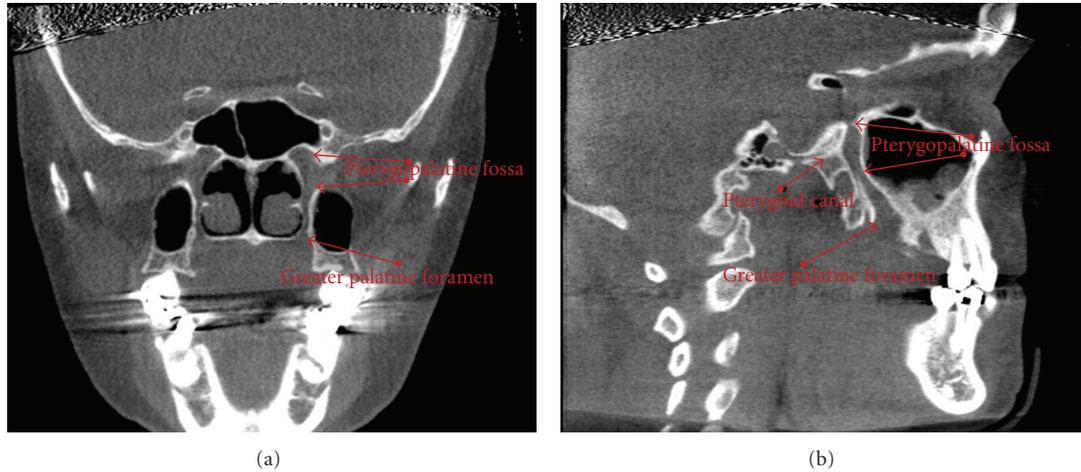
The images above demonstrate the appearance of anatomical structures on CBCT images described above; coronal view (a) and sagittal view (b). From the coronal view, the pterygopalatine fossa and greater palatine canal can be seen lateral to the nasal cavity. The pterygopalatine fossa begins below the middle cranial fossa and meets the greater palatine canal below which extends to enter the hard palate at the greater palatine foramen. In the sagittal view, the pterygopalatine fossa and greater palatine canal can be seen again, posterior to the maxillary sinus. The pterygoid canal is visible here, entering the pterygopalatine fossa from the posterior. The midpoint of the pterygoid canal was determined in this plane for each canal and used as the superior point of measurement.
